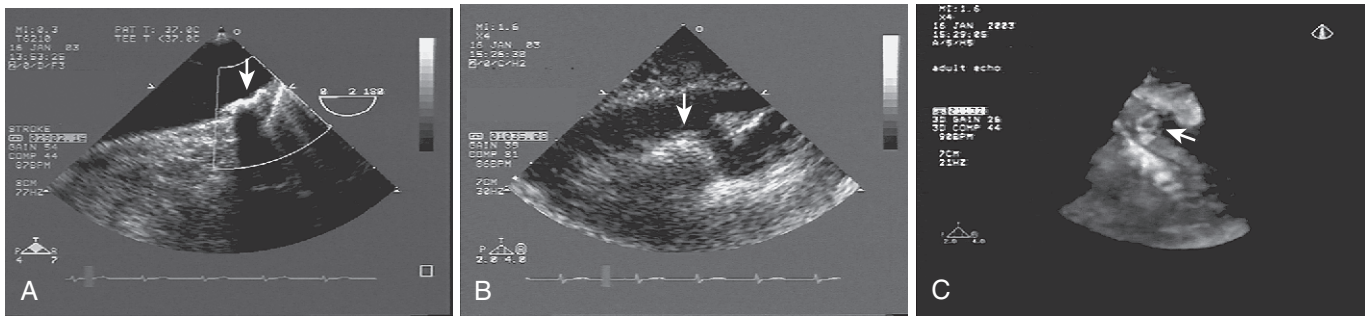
A, Transesophageal echocardiography visualization of a calcified plaque in the distal aortic arch. A large ulceration (arrow) is shown. B, Same plaque as in A, visualized from the suprasternal transthoracic approach. No definite ulceration is visible. C, Transthoracic three-dimensional imaging of the same plaque. Rotation of the transducer plane has allowed a better visualization of the plaque, and the entire area of ulceration (arrow) is now visible.
